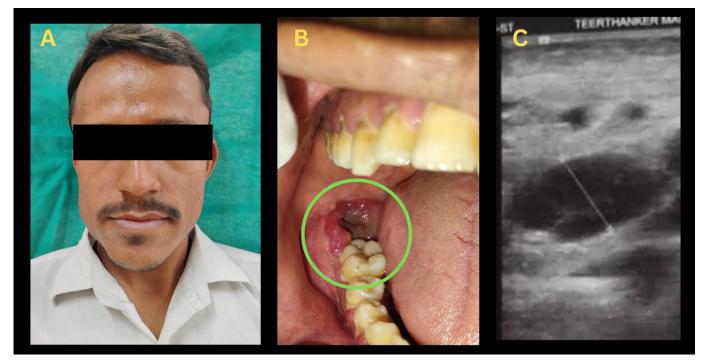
A. Extraoral swelling on left side of the face; B. Intraoral examination revealing a punched-out ulcerative lesion in the alveolar mucosa of the 47 region; C. Ultrasonographic examination revealing a homogenously hypoechoic jugulodigastric lymph node with loss of hilum.
